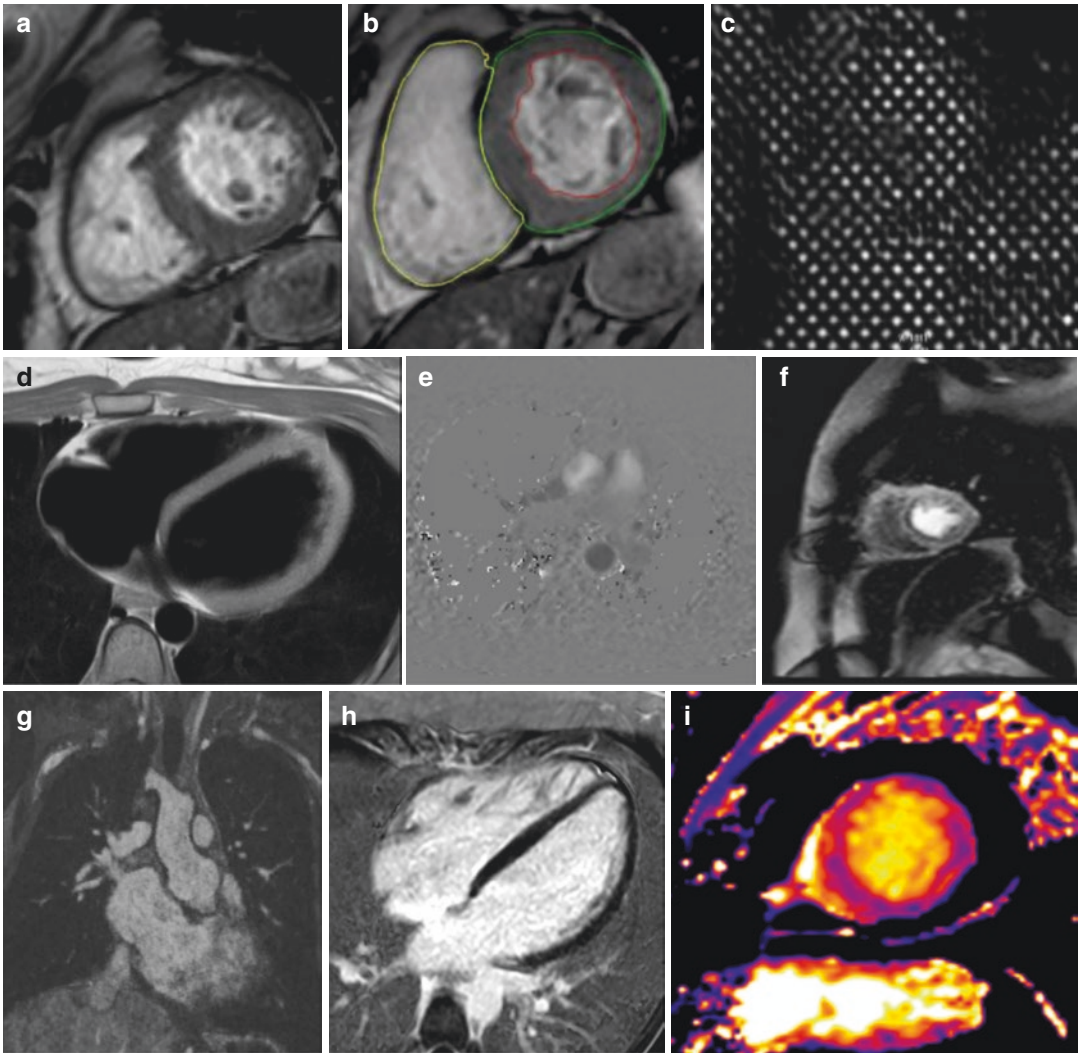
MRI sequences. (a) Cine SSFP sequence in the short axis plane. (b) Quantification of right ventricular volumes and function using contours drawn in systole and diastole. (c) Myocardial tagging image for regional cardiac function. (d) Black-blood sequence. (e) Velocity
